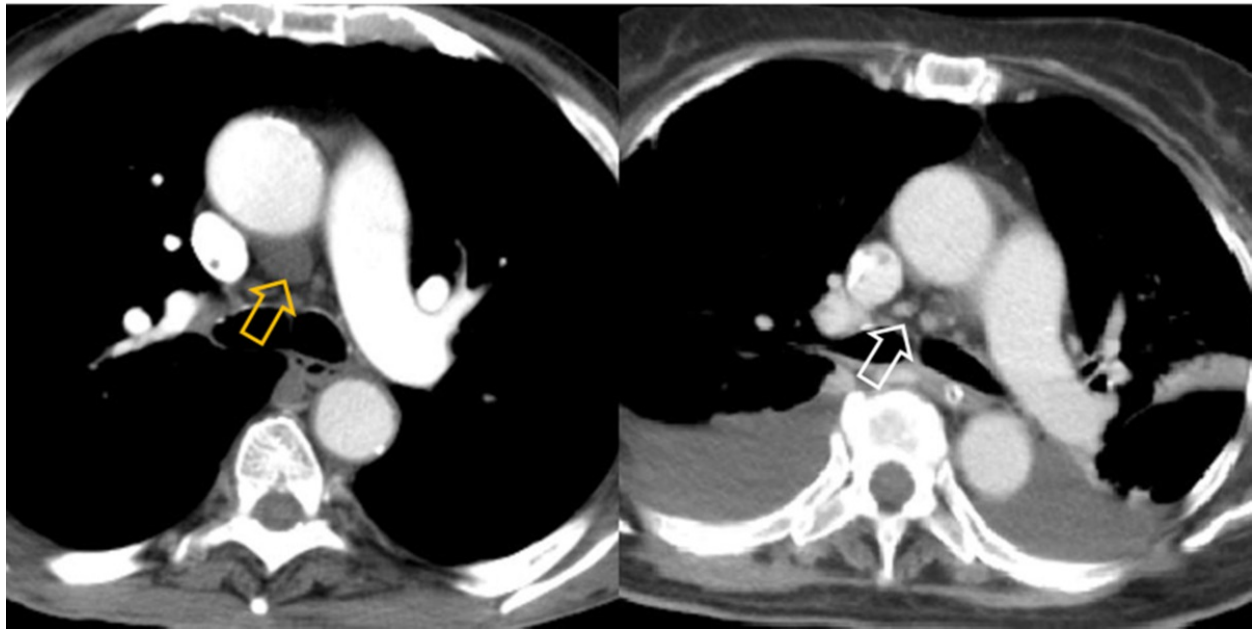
Axial CT images showing the characteristic pericardial recesses: sharply outlined structures with uniform water-equivalent attenuation without walls or rims in the expected anatomic location (orange arrow) and enlarged lymph nodes with a more round shape with peripheral enhancement (white arrow).
